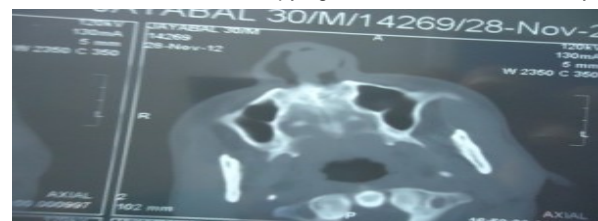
Shows CT-paranasal sinus reveals a large soft tissue mass in the left nasal cavity. Nasal septum deviated to right side due to mass effect of tumour. For further evaluation biopsy was taken from the mass considering the following as differential diagnosis 1.Neurofibroma 2.papilloma 3.Angiofibroma 4.Solitary Fibrous Tumours 5.Hemangiopericytoma 6.Fibroma 7.Malignant Tumours and 8. Meningioma.
